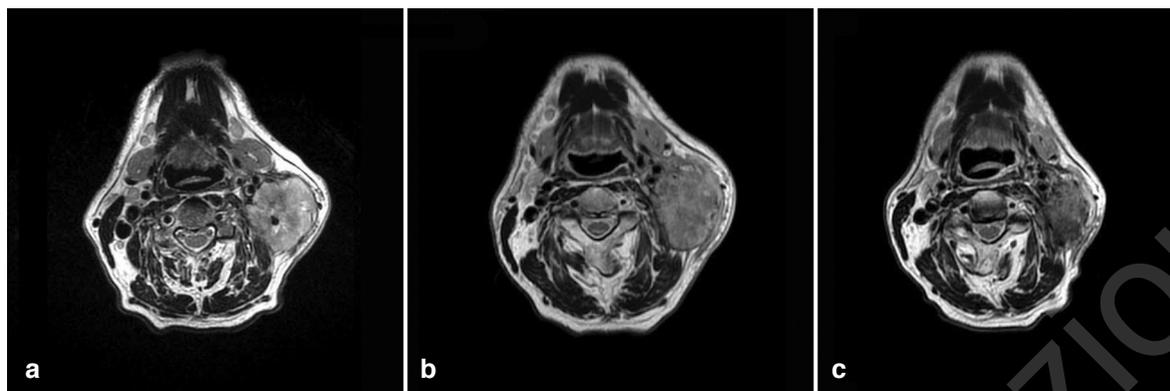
MRI TSE T2 weighted images pre CHT-RT (a), during (b) and after therapy (c) in N3 node in patient with a small (T1) hypopharyngeal tumor. There is an increase dimension of the node during therapy (b) and the reduction of the dimension of the node after therapy (c -same day of the end of radiotherapy).
